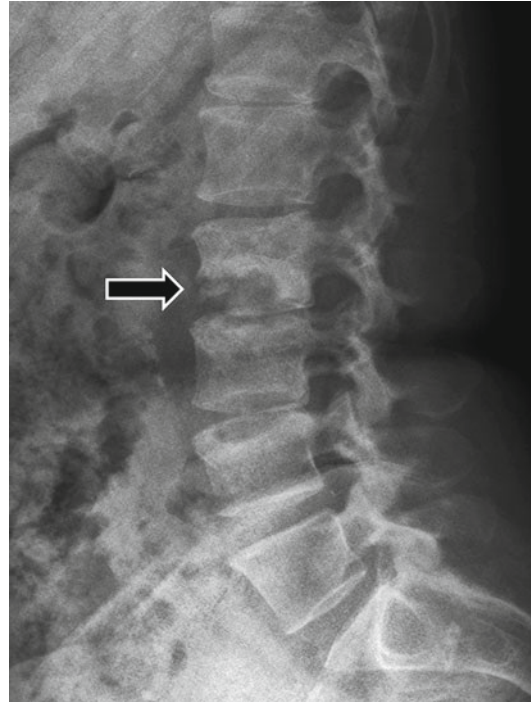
A 25-year-old female with increasing, now severe, low back pain and fever. The L2–3 disk space demonstrates destruction of both adjacent endplates (*black arrow*). This is a very specific radiographic appearance of diskitis as very few entities other than infection cause a disk-centered destructive process
